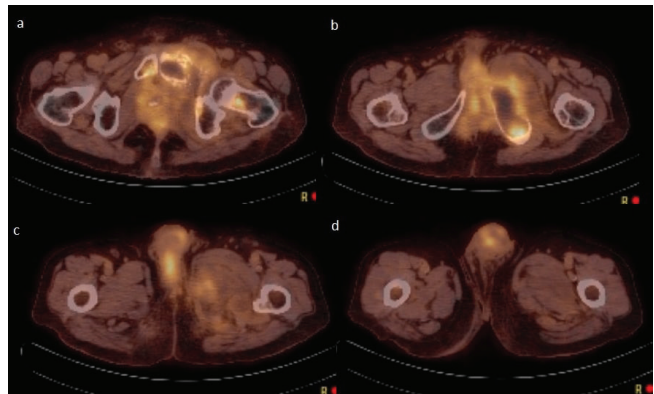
FDG PET CT indicates that the rectum carcinoma metastasizes to the bones and soft tissues. a. Recurrence at pelvic area and destruction at pelvic bones. b. The relapsing mass extended to the anal canal. c. Metastasis at the root of the penis. d. Metastasis at the shaft of the penis.
